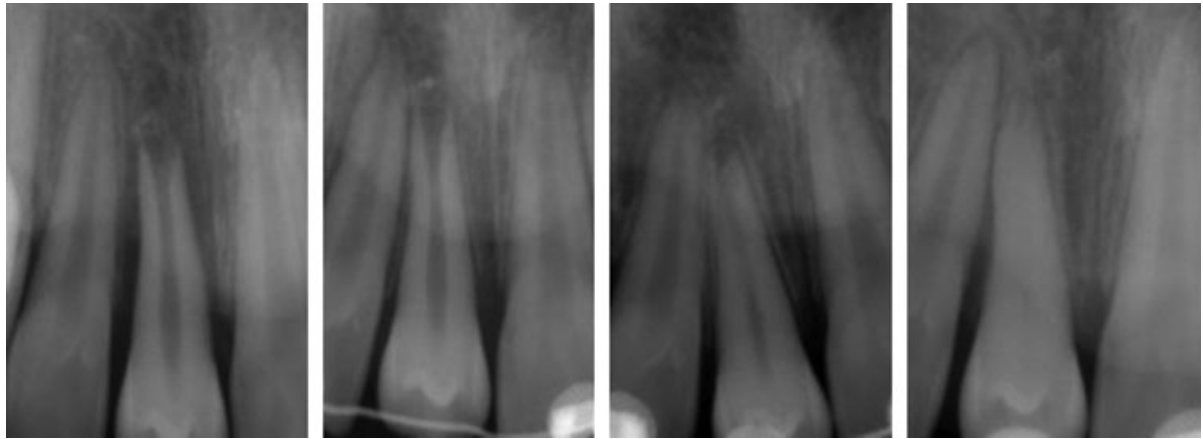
Radiographs: day of transplantation, 3, 8 and 18 months after transplantation (from left to right), increasing obliteration of the pulp.
